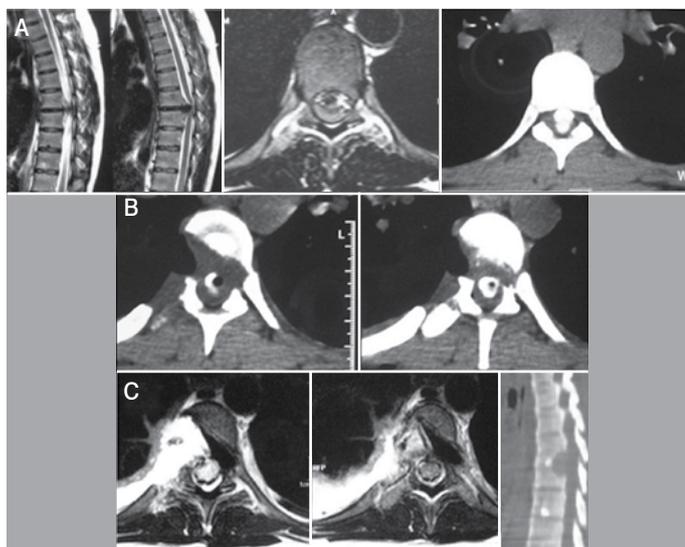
Pre- and postoperative imaging exams: (A) Sagittal/axial MRI in T2 and CT show a calcified hernia of the central thorax with medullary compression; (B) Postoperative CT showing partial removal of the herniation; (C) MRI and CT following the second surgery showing complete resection of the disc hernia (Patient 3 in Table 1).
